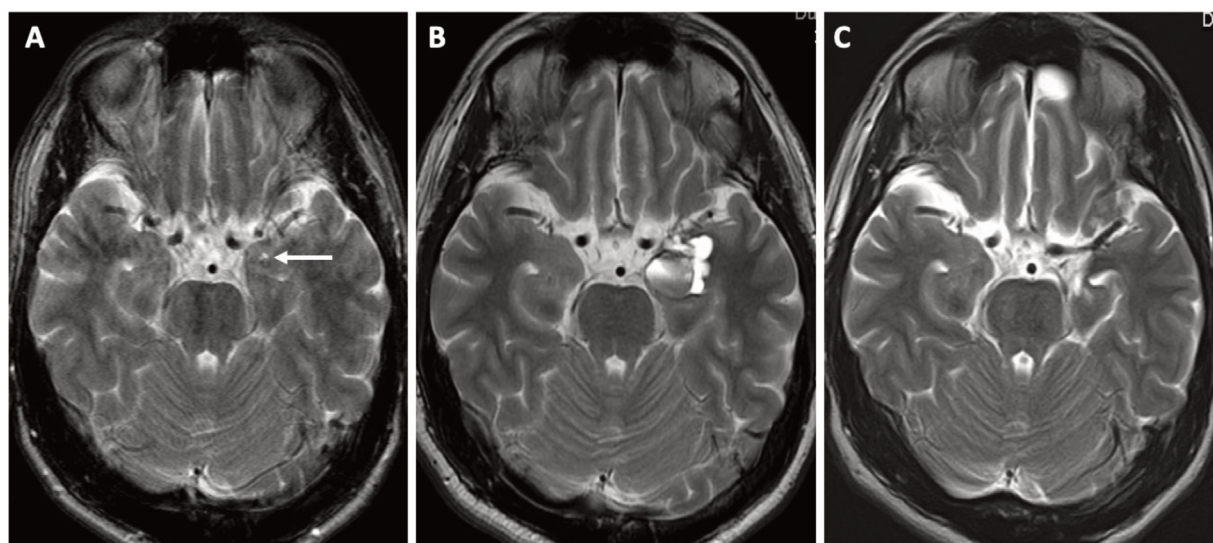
Case 2. T2-weighted MRI images. Images taken 18 months before surgery (A) and before surgery (B) show an increase in the size of a left temporal cavernoma. Postoperative follow-up image shows removal of the cavernoma (C).
